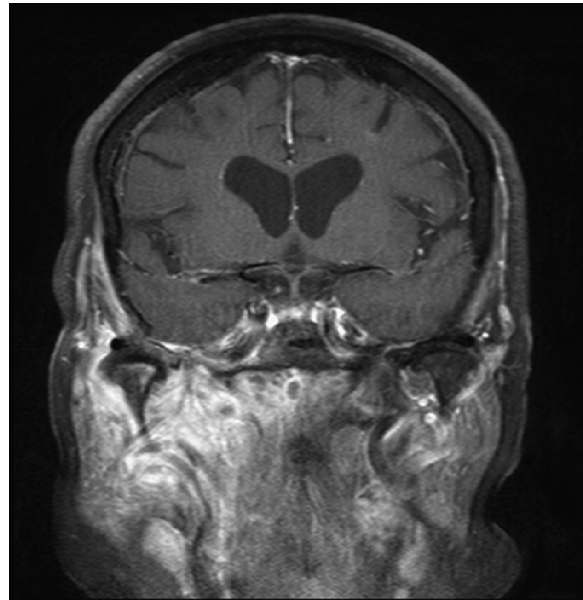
Coronal magnetic resonance image of the brain shows significant soft tissue infiltration and edema involving the infra-temporal fossa, masticator, parotid and parapharyngeal spaces, right temporalis muscle and subcutaneous soft tissues. Associated mild dural enhancement of the floor of the right middle cranial fossa.
